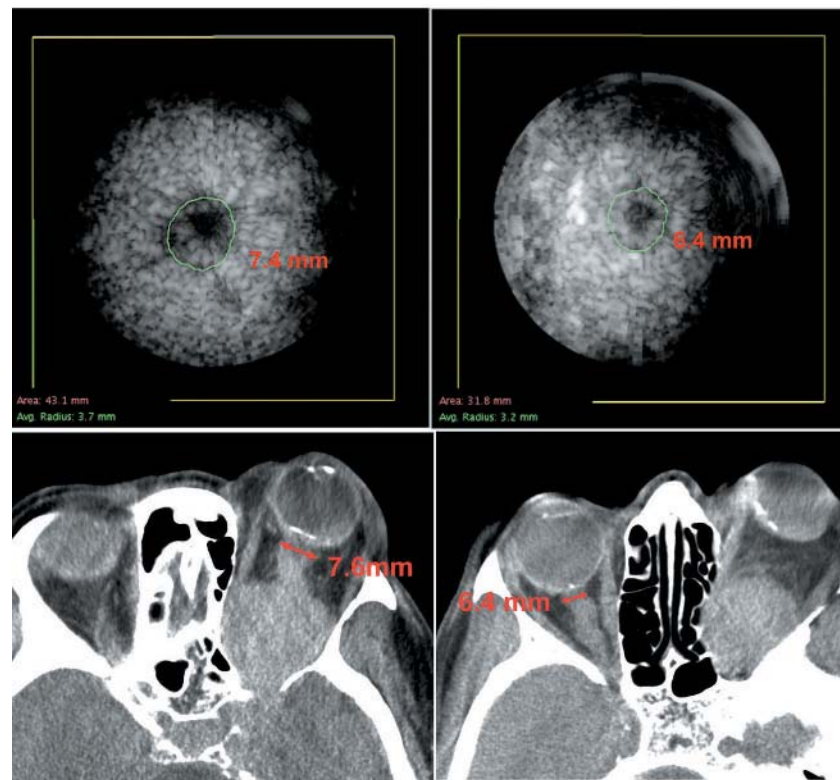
Case 1. The patient's left (top left) and right (top right) optic nerve sheath diameters are shown by 3DUS coronal C-scans. The patient's left (bottom left) and right (bottom right) optic nerve sheath diameters are shown by axial CT scans.
